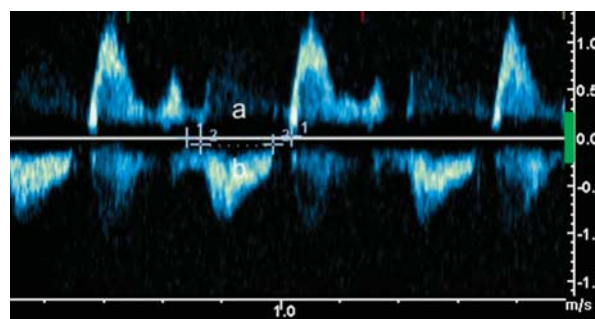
Echocardiographic measurements from of one of our patients, showing the calculation of the Tei index.
